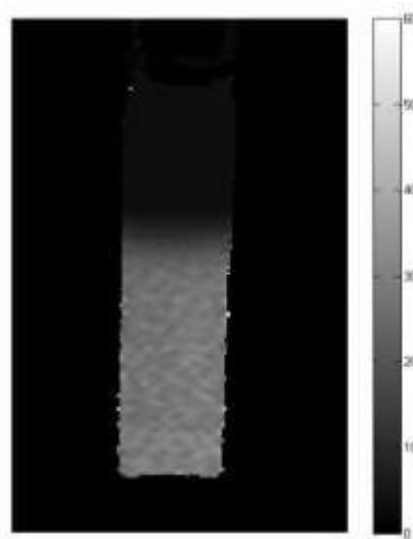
MRI slices of calibration test tubes
